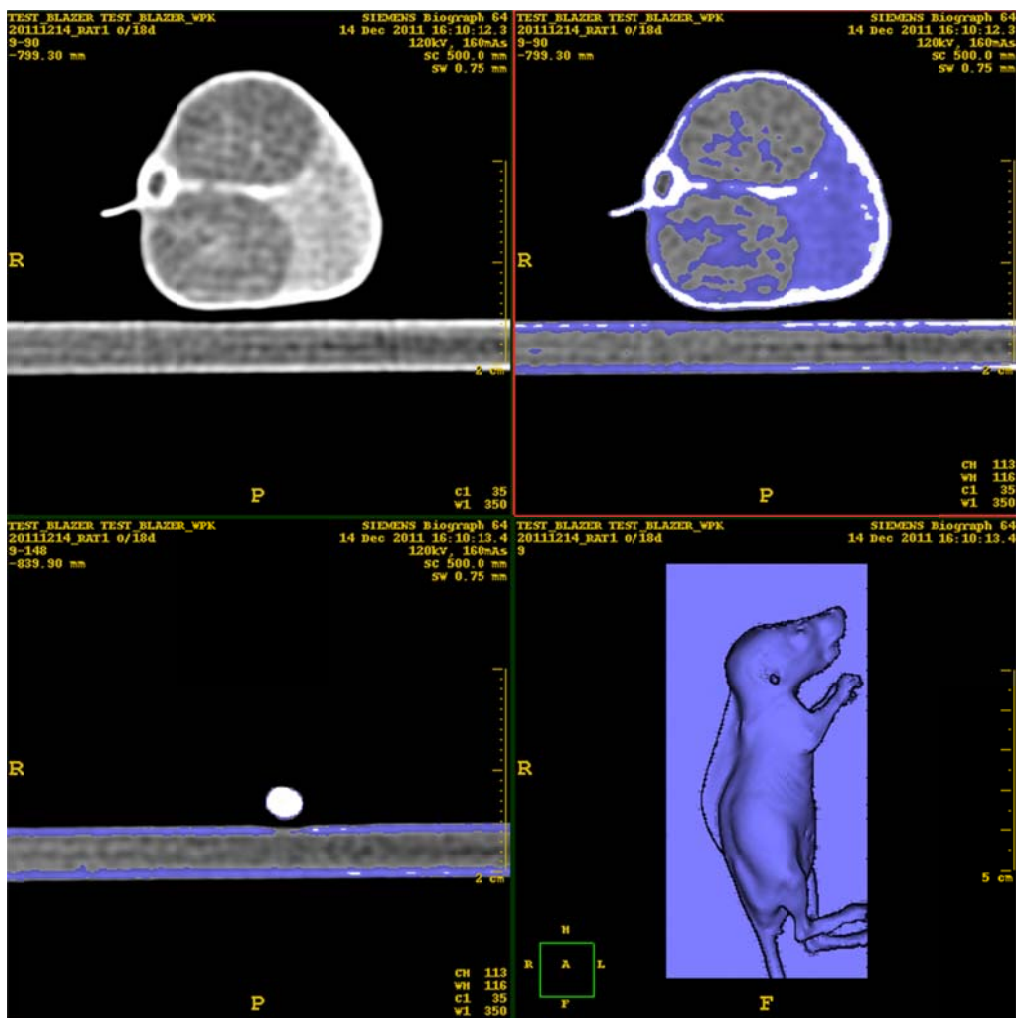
18 Day Pioglitazone 2-D Image of CT values labeling for normal tissue from Philips program
